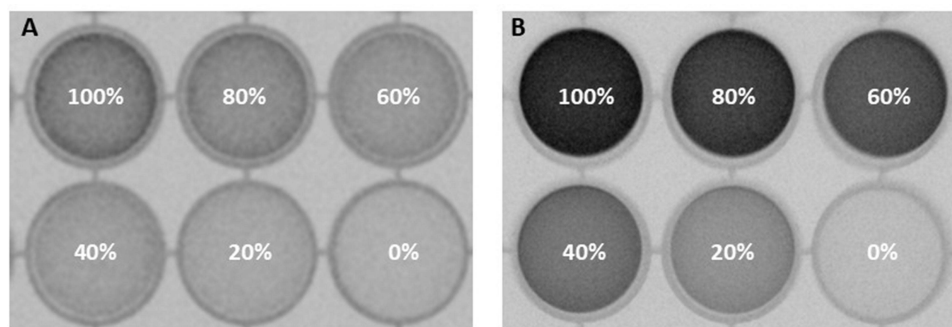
X-ray images showing varying concentrations of both, GA and IB contrast media. Different concentrations in a range of 0–100% of GA (A) and IB (B) were measured by X-ray with Ziehm Vision RFD 3D (Ziehm Imaging, Nürnberg, Alemania) equipment. Dilutions were made in NPCM.
